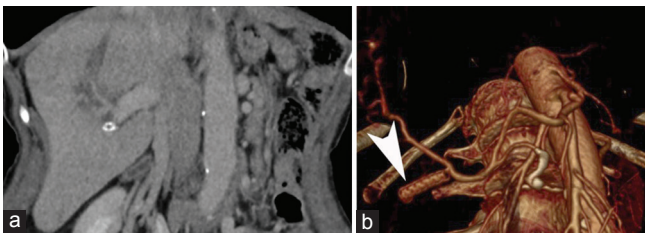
Computed tomography 4 months after stent-graft placement. (a) Resorption of the hematoma. (b) No flow through the stent graft (arrowhead)
